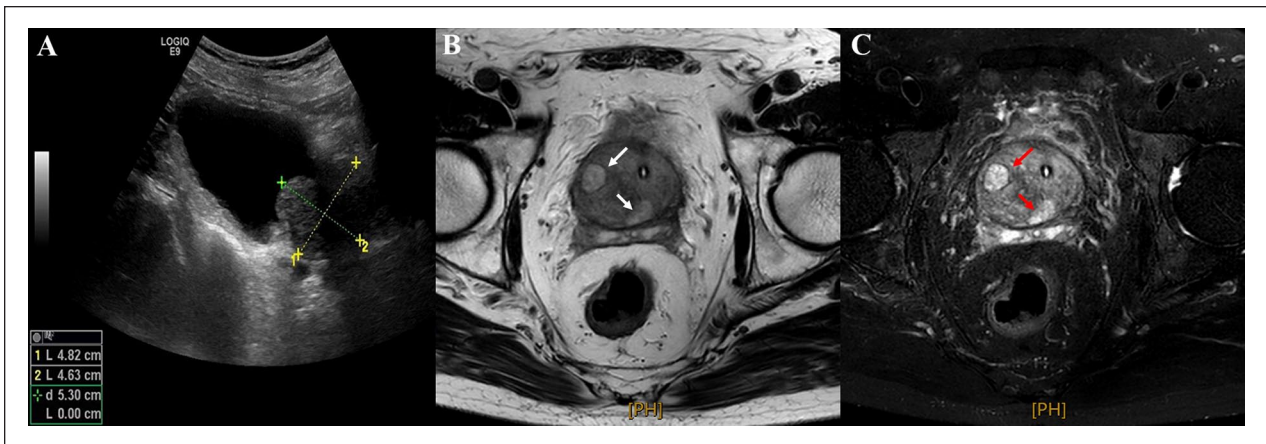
Ultrasound and MRI Images
